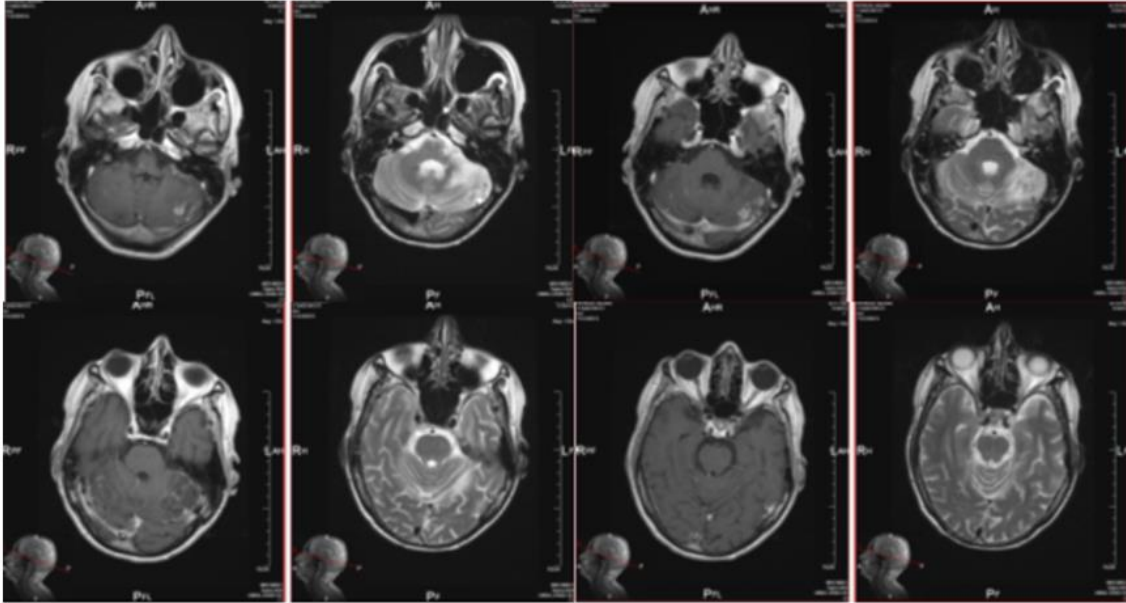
AX T1 FLAIR+C postcontrast and AX T2 MR images after 4 months of RT and after 3 months of targeted therapy alone
